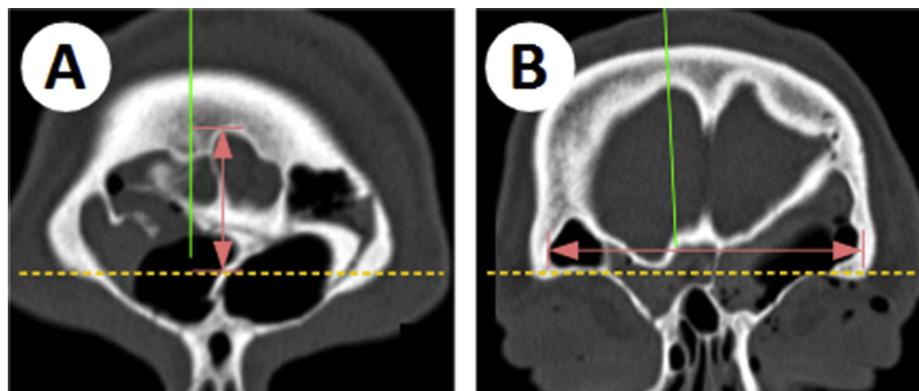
Measurements of maximum frontal sinus height (A) and width (B); reference for height is the supraorbital line (Schmittbuhl and Le Minor, 1998); CT images in coronal view.
